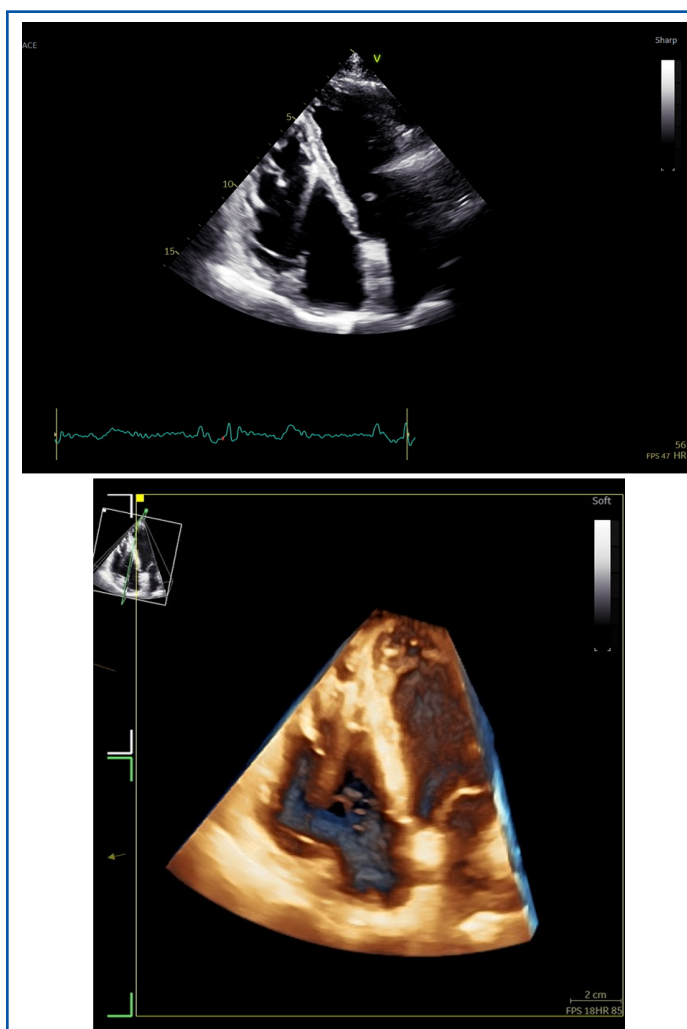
Transthoracic 2D (A) and 3D (B) echocardiography, showing dilated RV. 2D, two-dimensional; 3D, three-dimensional.
